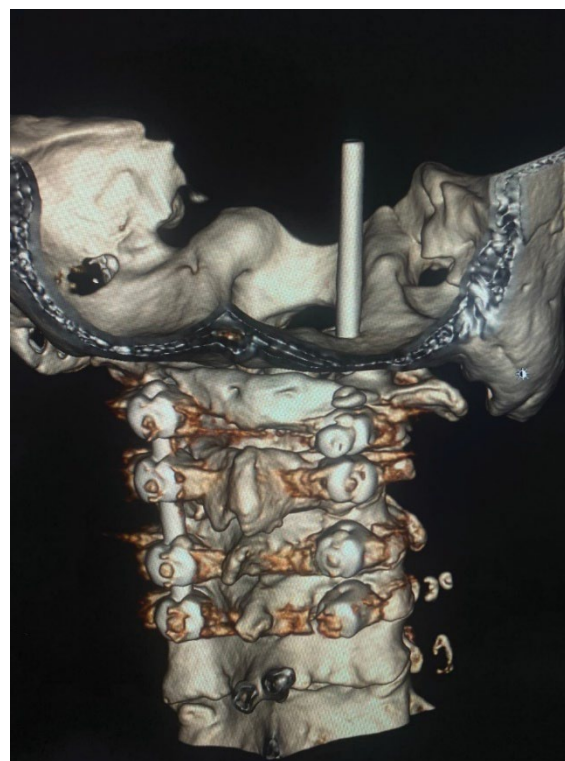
Computed tomography of the cervical spine with migration of the rod into the posterior cranial fossa
